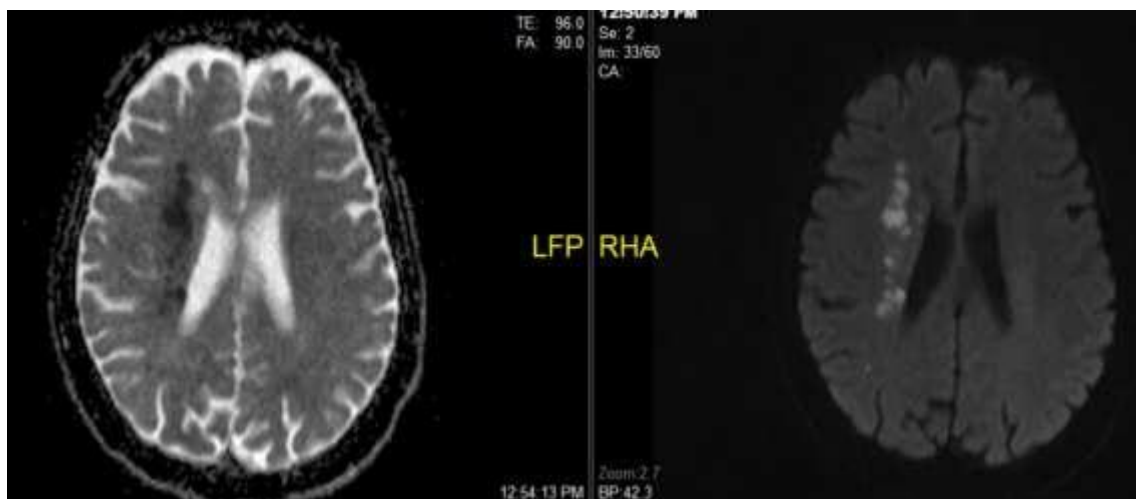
CT NECK AND BRAIN ANGIOGRAM IN OUR HOSPITALISED COVID-19 PATIENT SHOWS A) ACUTE INFARCT IN RIGHT CORONA RADIATA AND B) RIGHT MCA OCCLUSION
